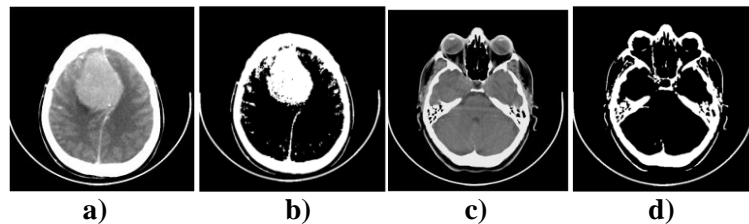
17 Thresholding algorithm applied to CT slice. a) original image, b) thresholded image, c) original image, d) thresholded image.
